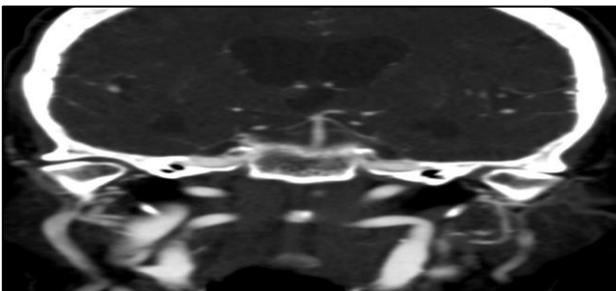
Coronal contrast CT angiography MIP image showing right sided fetal origin of PCA with hypoplastic p1 segment.
